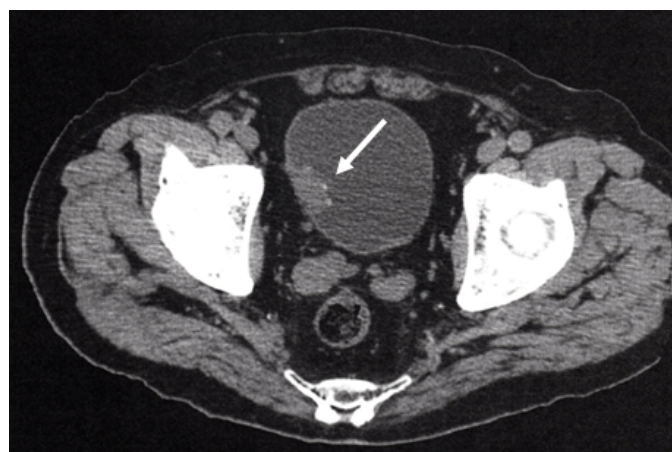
Plain computed tomography scan of pelvic. Arrow head showing surface calcification of urinary bladder cancer.
